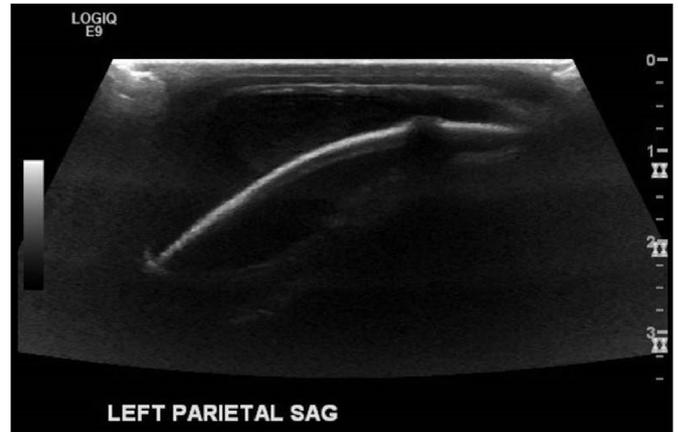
Ultrasound view of subgaleal hemorrhage. Note fluid extending beyond the suture line. Courtesy of Amy Mehollin-Ray MD.
